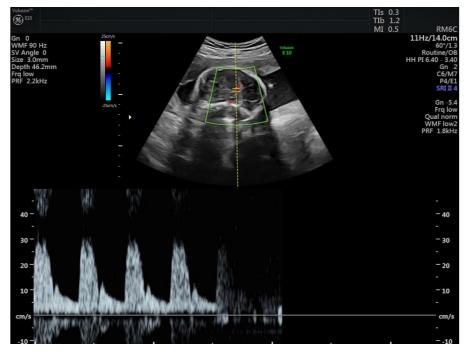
2D Fetal Doppler echocardiography showing the atrioventricular canal defect.
